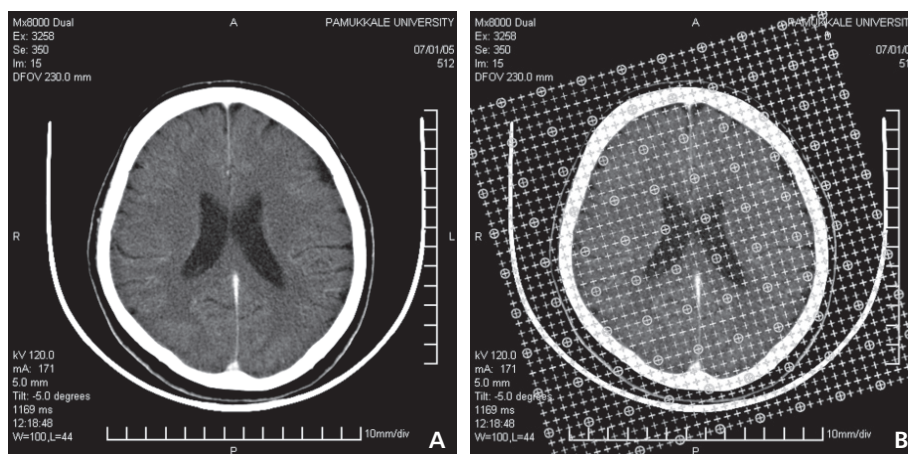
A. A transverse computed tomography (CT) image of the brain; B. Same CT image with a combined point-counting grid superimposed on it for the estimation of volume and volume fraction of the ventricles and brain sites.
